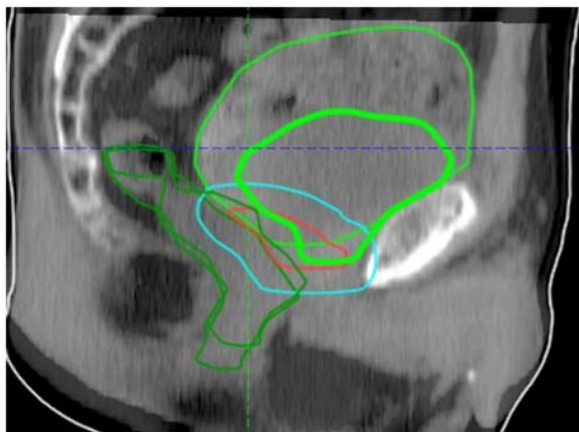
An example of a patient with large variation in bladder filling between planning CT (thin light green) and CBCT before a treatment fraction (thick light green). The planning-CT and CBCT are matched to bony anatomy. (Red =CTV, blue=PTV, dark green= rectum)
